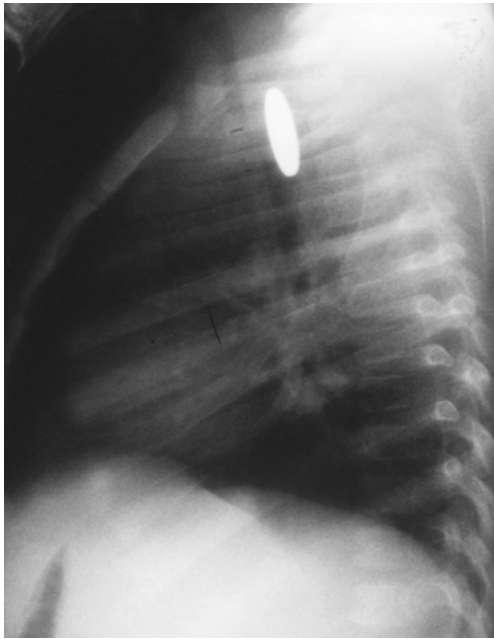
Lateral chest radiograph of a 2-year-old child with an upper esophageal foreign body (coin). Note the secondary narrowing of the trachea due to edema of the tracheoesophageal membrane.
